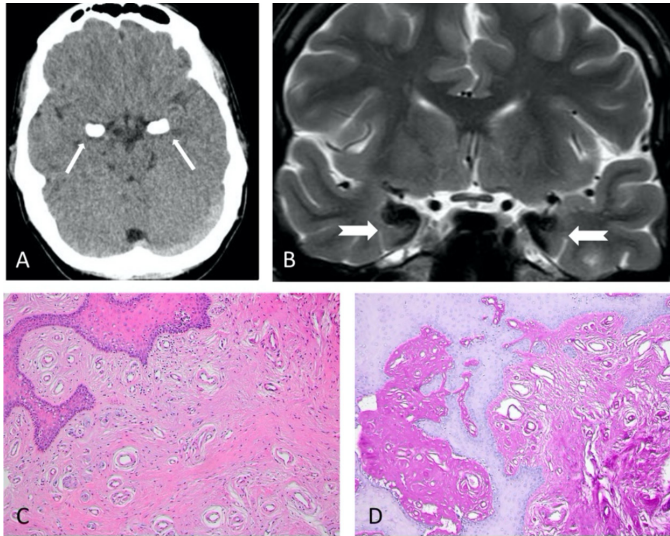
Bilateral amygdaloid calcifications (arrows) detected by cranial computed tomography scanning (A); bilateral comma-shaped hypointense lesions (arrows) on brain magnetic resonance imaging (B); homogenous eosinophilic material around blood vessels and in the dermis. H & E x 200 (C); hyaline-like material is periodic acid-Schiff (PAS) positive and diastase resistant. d-PAS x 200 (D)
